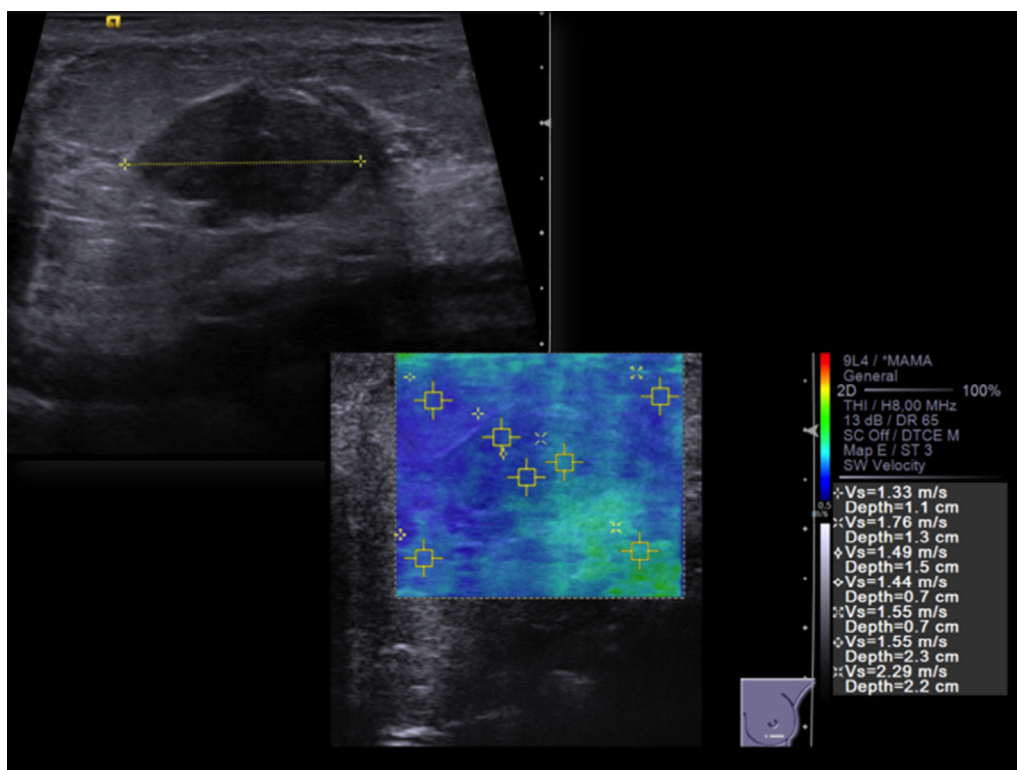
Example of a breast lesion in B-mode ultrasonography image (*left*), as well as a color elastogram superimposed with the underlying B-mode image and the respective measurements of shear wave velocity (*right*), which are low (<4.5 m/s). The pathological result was fibroadenoma.
